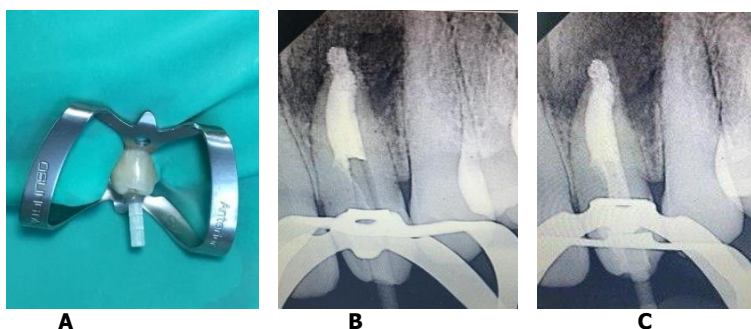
A. Fiber post insertion; B. Try-in radiograph of the fiber post; C. Fiber post insertion radiography
